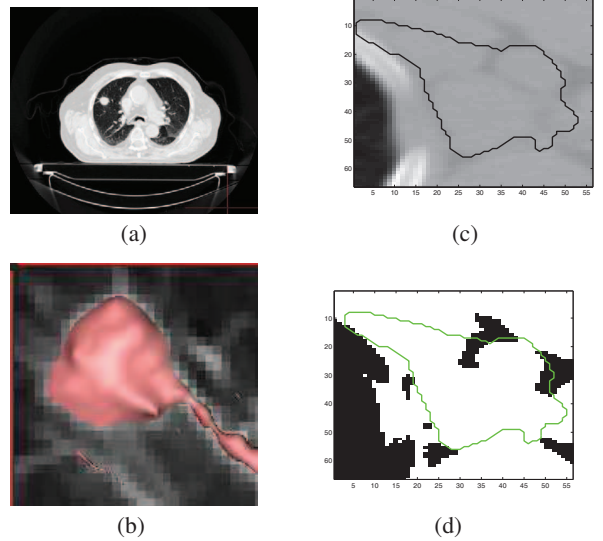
Left: (a) Lung CT data and (b) automated tumor segmentation with prior masking of non-lung tissues. Right: (c) Thoracic lymph node CT data and (d) comparison of manual segmentation (green contour) and automated segmentation (binary mask).
